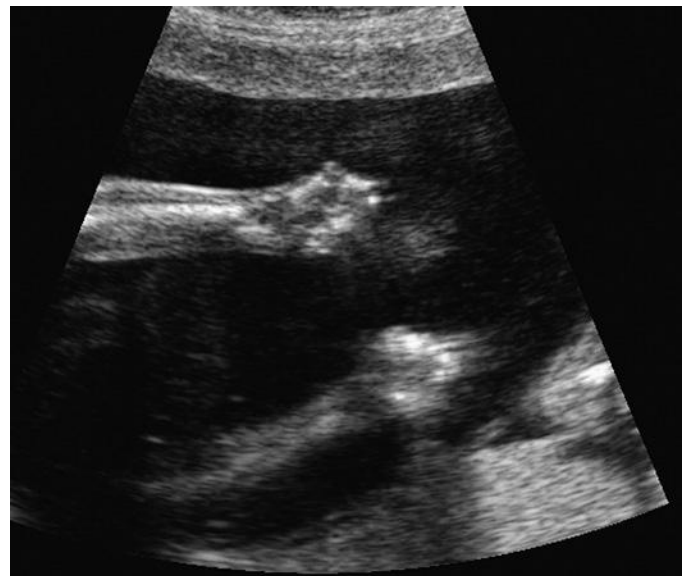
Sonogram of fetus with trisomy 18 shows bilateral clenched hands, which persisted throughout the sonographic examination.
